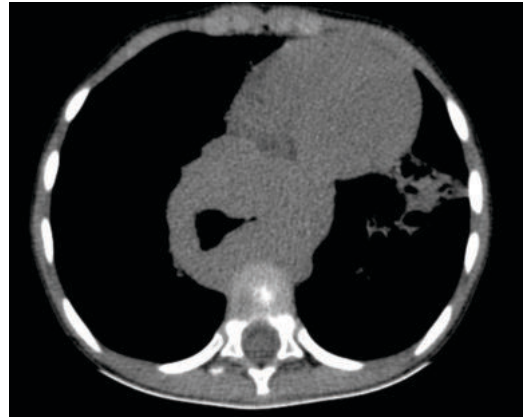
Axial CT Section In Mediastinal Window, Showing Circumferential Wall Thickening Of The Esophagus.
